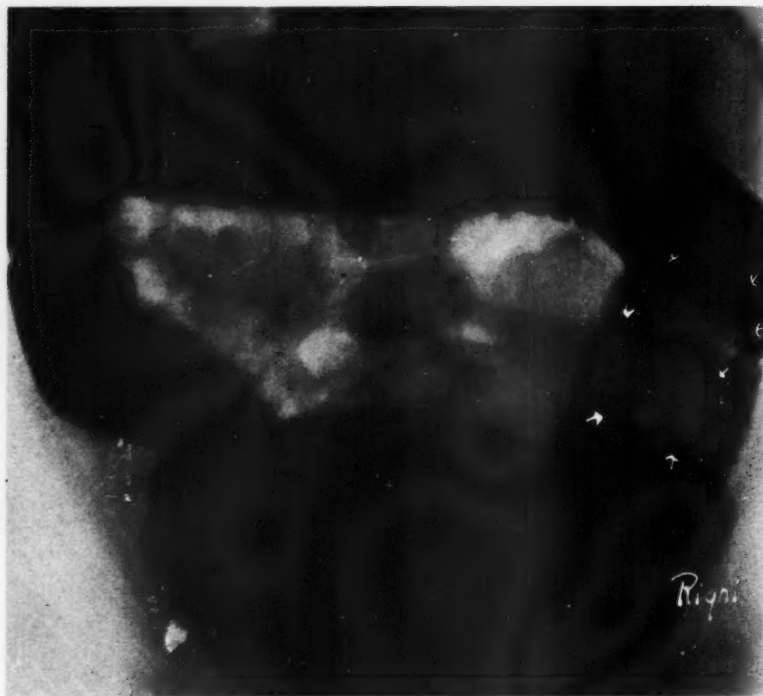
S. P., female baby, 14 months old. Barium enema showing large sharply defined defects of the cecum and ascending colon caused by intussusception of ileum into the colon. Compare these roentgen symptoms with those of Figures 4, 5, and 6.
